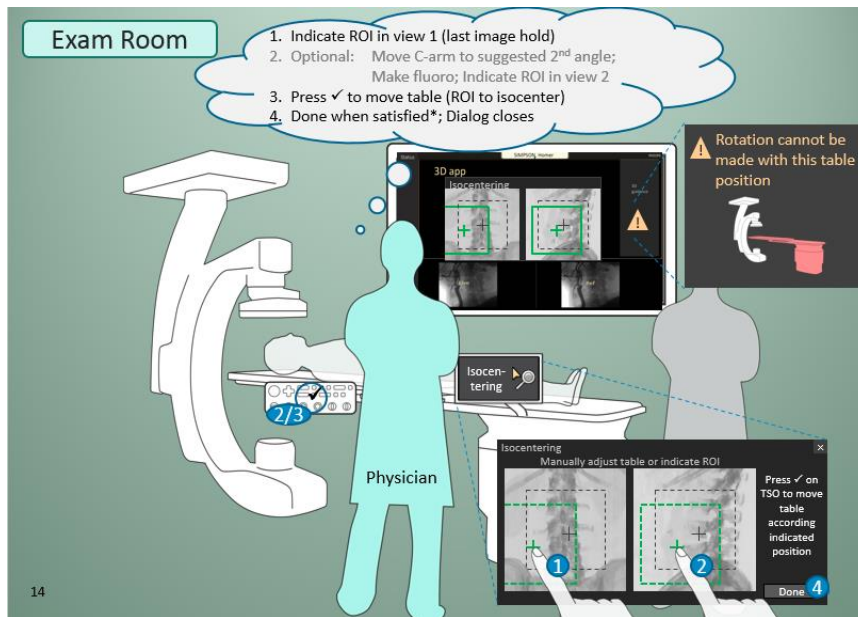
Guided user interaction between physician and the X-ray imaging system
